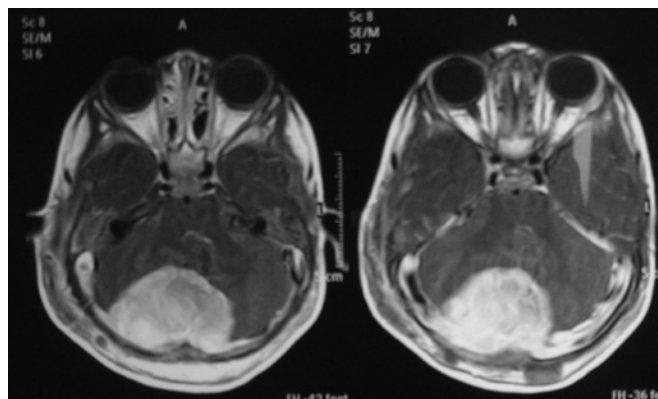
MRI showing intense contrast uptake and encephalic compression.
